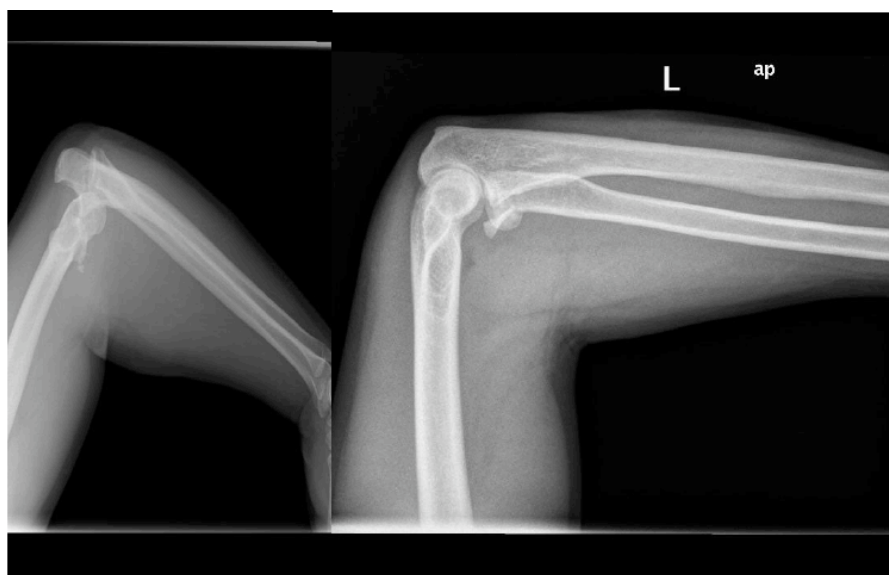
Shows an example of a series malignant triad collection our study. It is a lateral radiograph of a posterior dislocation radio head fracture of the radial head and the coronoid. b: This is another example of TTC. It can be appreciated fracture coronoid process more than 50%.
